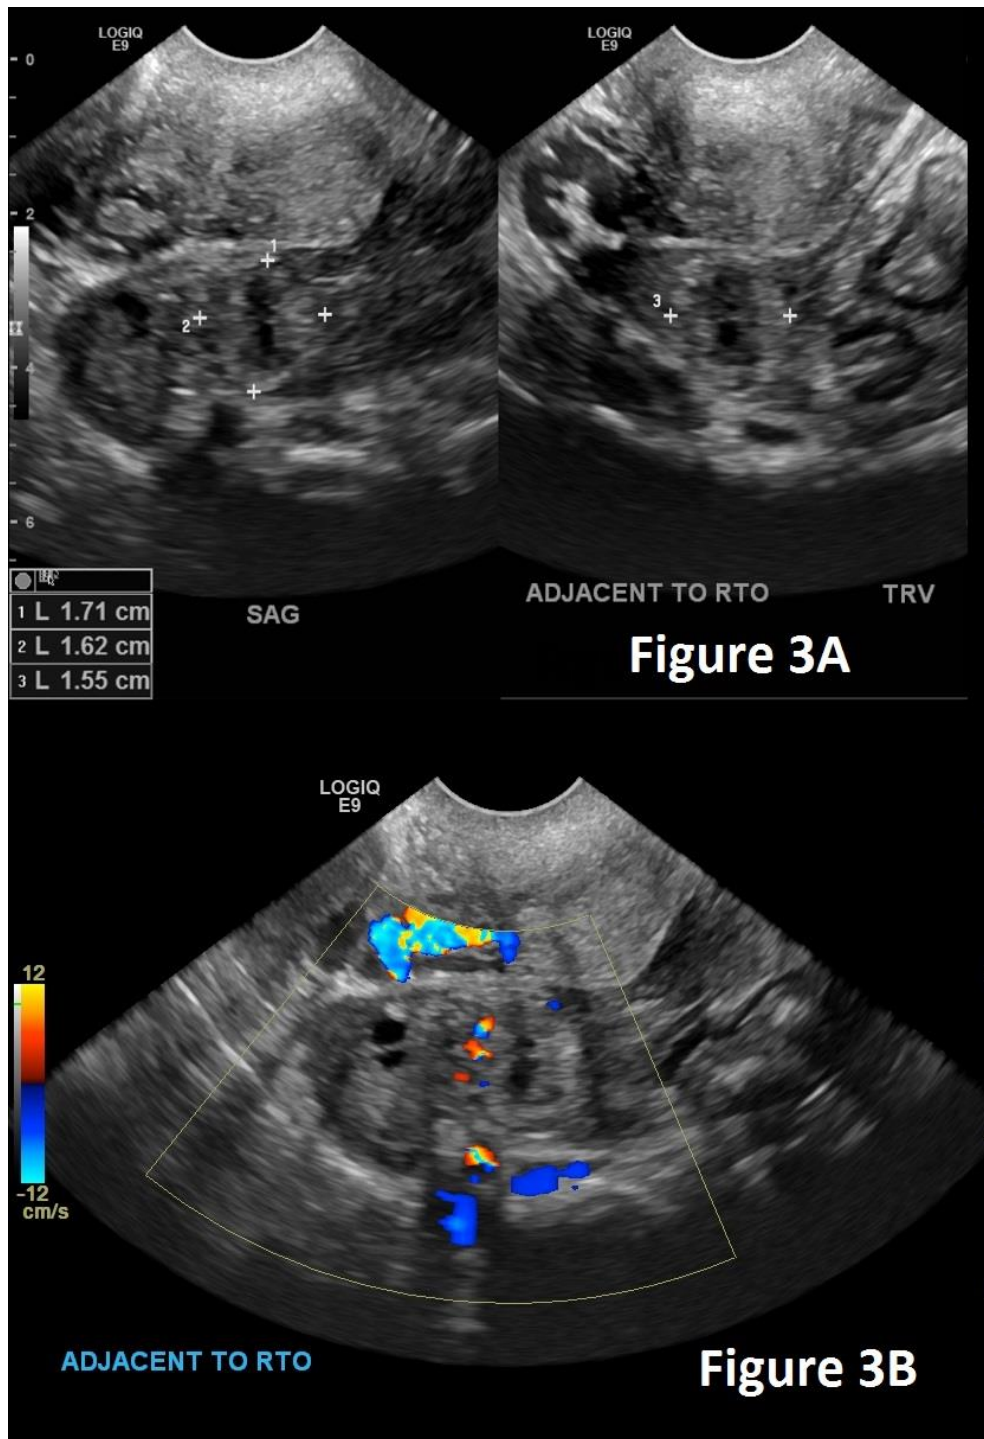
Hemorrhagic heterotopic pregnancy in 35 year old female with a history of prior tubal ligation and re-anastomosis. Findings: Figure 3A demonstrates sagittal and transverse images of a thick-walled cystic structure in the right adnexal region measuring approximately 1.71 x 1.62 x 1.55 cm. This structure was shown to be separate from the right ovary. Figure 3B color ultrasound demonstrates vascularity of the structure. Technique: Transvaginal Ultrasound. Study performed with the General Electric Logiq E-9 ultrasound system with the IC-5 probe at 8 MHz.
